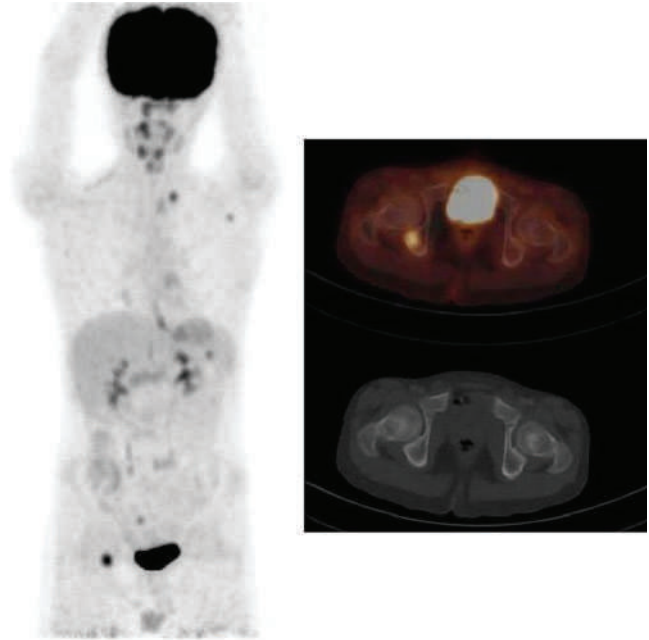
Fluorine-18-fludeoxyglucose (¹⁸F-FDG)-positron emission tomography/CT shows an FDG-avid focus in the right ischium in the maximal intensity projection and transaxial fusion images. The corresponding CT image shows no matching abnormality. FDG-avid disease identified in the left supraclavicular region, the left axilla and the spleen. Bone marrow biopsy was negative in this patient.
